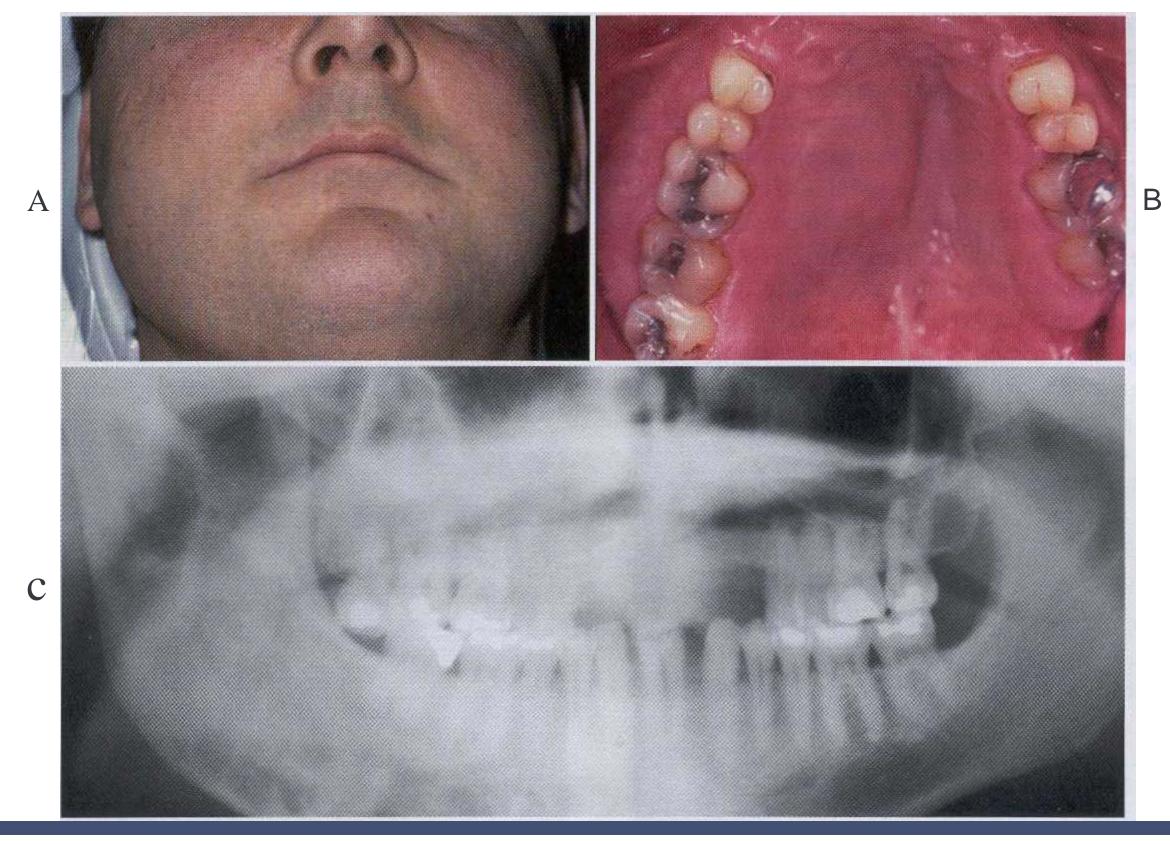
• Polyostotic fibrous dysplasia. jaffe-Lichtensteln syndrome: A. young man exhibiting enlargement of the right maxilla and mandible; B. intraoral photograph showing unilateral maxillary expansion; C. panoramic radiograph showing ill-defined lesions of the right side of both Jaws.
